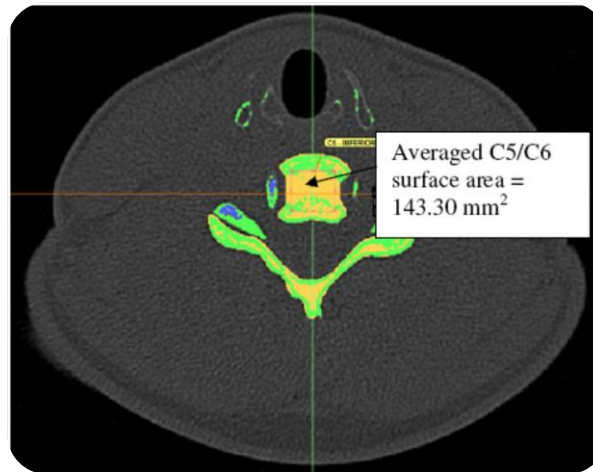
Cross-sectional area in the transverse plane of vertebral bodies in a CT scan using MIMICS™ [15]
